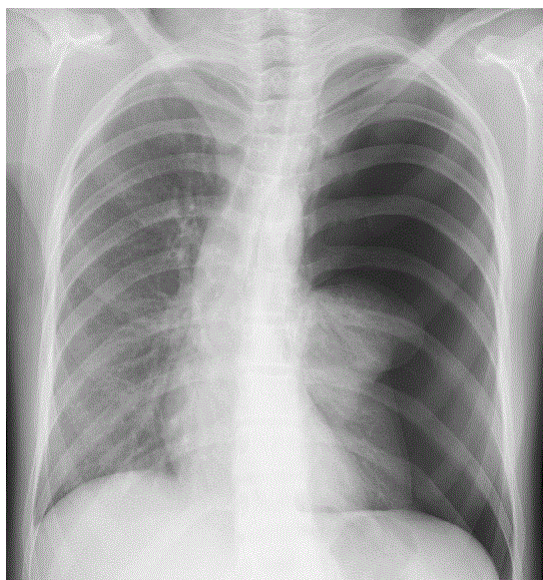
Chest X-ray of patient at 9 years of age. Collapsed left lung is seen with right side deviation of the mediastinum. No other lesions were present in the lungs.
